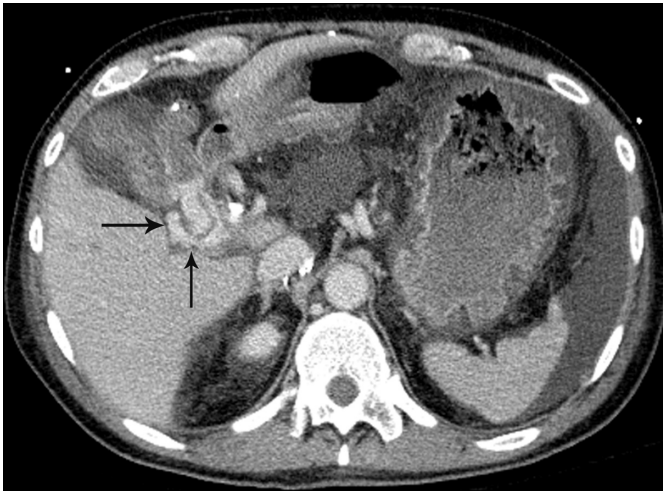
Computed tomography scan demonstrating varices (arrow) in the jejunum.
